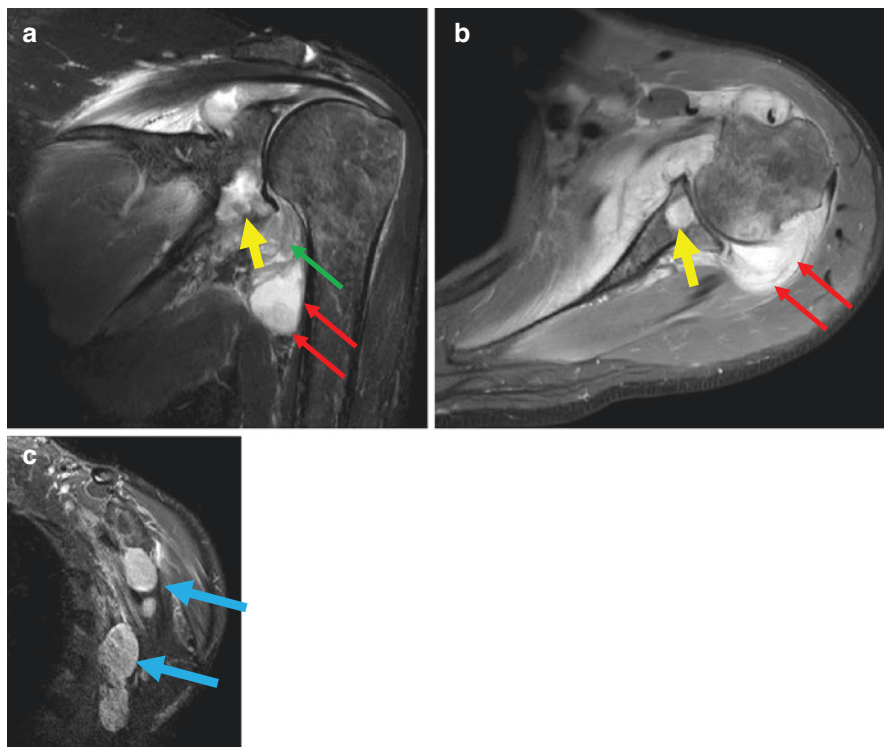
Left Shoulder Tubercular arthritis MRI: Image a & c—Coronal STIR, Image b Axial SPAIR (All fluid sensitive sequences). Large complex mixed signal left shoulder effusion distending the capsule (red arrows) with marked synovial thickening (green arrow) and surrounding soft tissue oedema. Associated glenoid high signal reflects bone lysis (yellow arrows). Associated bulky axillary lymph nodes (blue arrows, Image c). *Image courtesy Dr Michael Khoo, Consultant Radiologist, Royal National Orthopaedic Hospital, Stanmore, UK*
